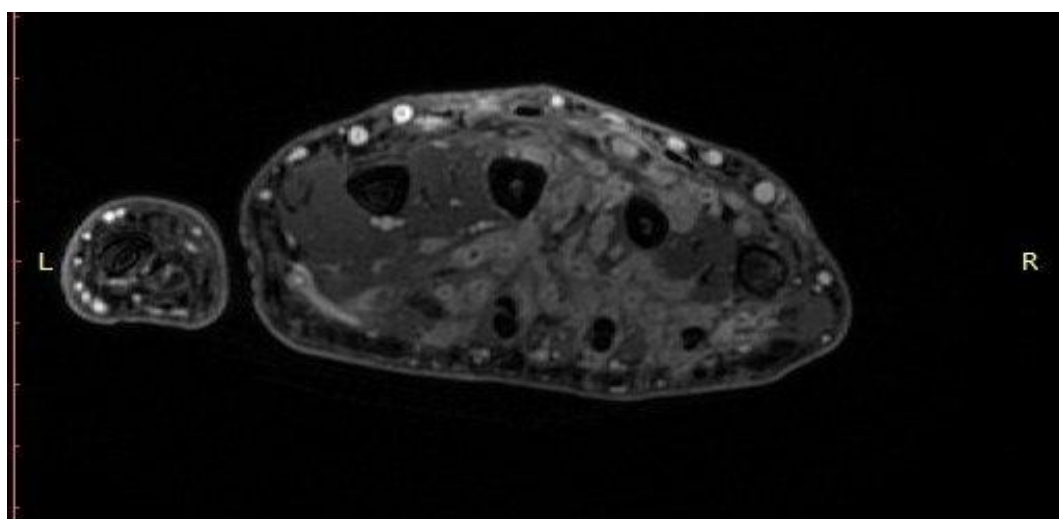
Axial T1-weighted fat-suppressed post-contrast MRI image of the hand demonstrating multiple small, rounded enhancing lesions with central hypointense foci within the soft tissues, along with surrounding inflammatory enhancement consistent with the “dot-in-circle” sign, suggestive of mycetoma.
